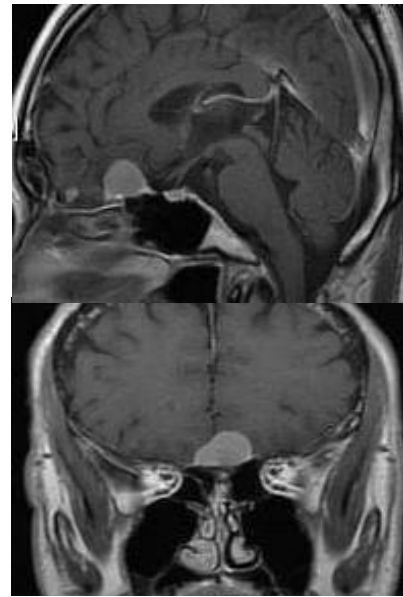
Female patient of 55 years presented with decreased visual acuity associated with headache (Preoperative MRI Sagittal and coronal images showing tuberculum sella meningioma).
